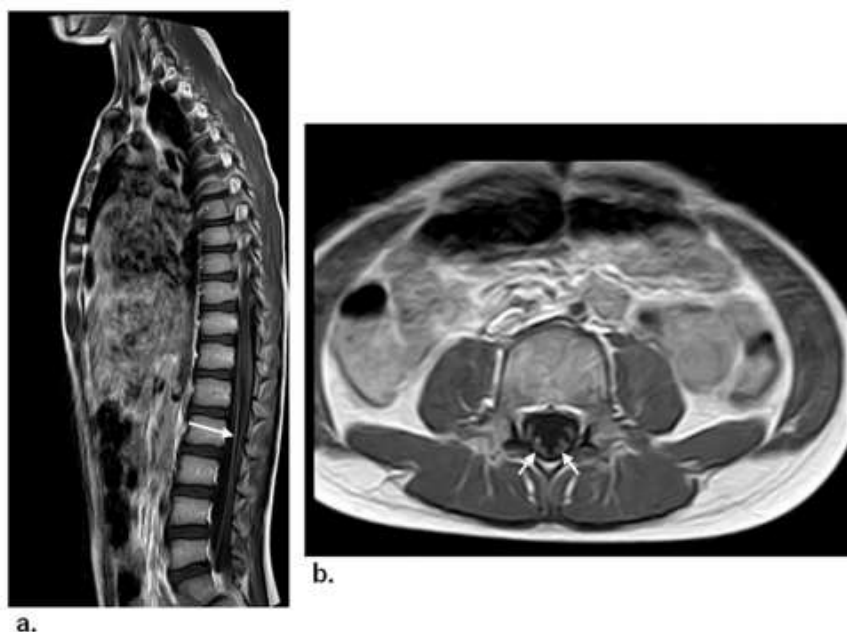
A 6-year-old boy diagnosed with MIS-C exhibited fever, diarrhea, and flaccid paralysis. Post-contrast MRI demonstrated: (a) Sagittal and (b) Axial T1-weighted images showing abnormal enhancement of the cauda equina nerve roots (arrows) [67].
